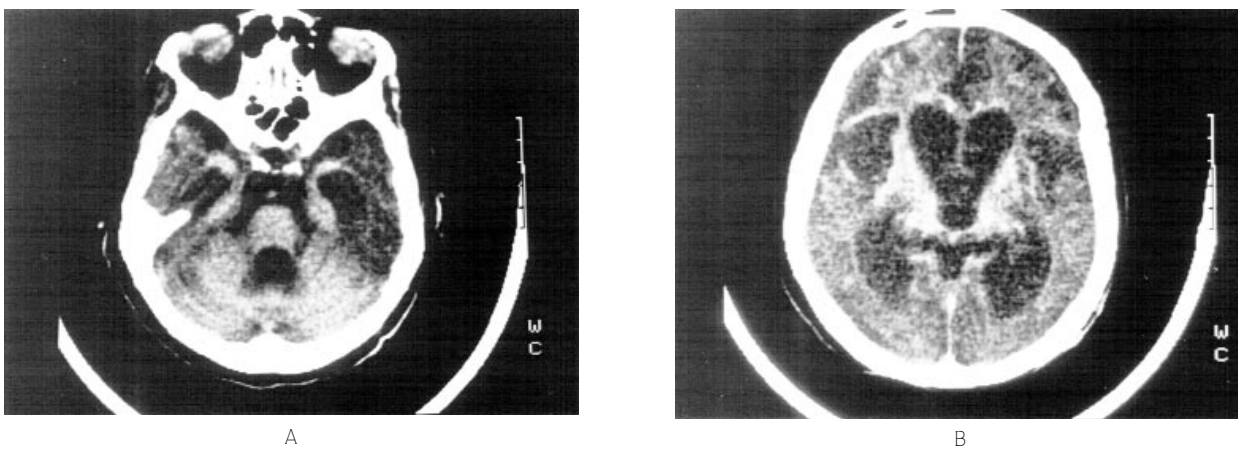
Late follow-up axial CT scans (A-B) show diffuse bihemispherical cerebral and cerebellar cortical atrophy, ventricular dilatation, marked hypodensity of gray and white matter with relative hyperdensity in the thalami, brain stem and cerebellum, and loss of gray/white matter interface. In the basal ganglia region, there were also small hypodense areas due to microinfarcts with small, patchy, hyperdense areas due to pigment deposition.
